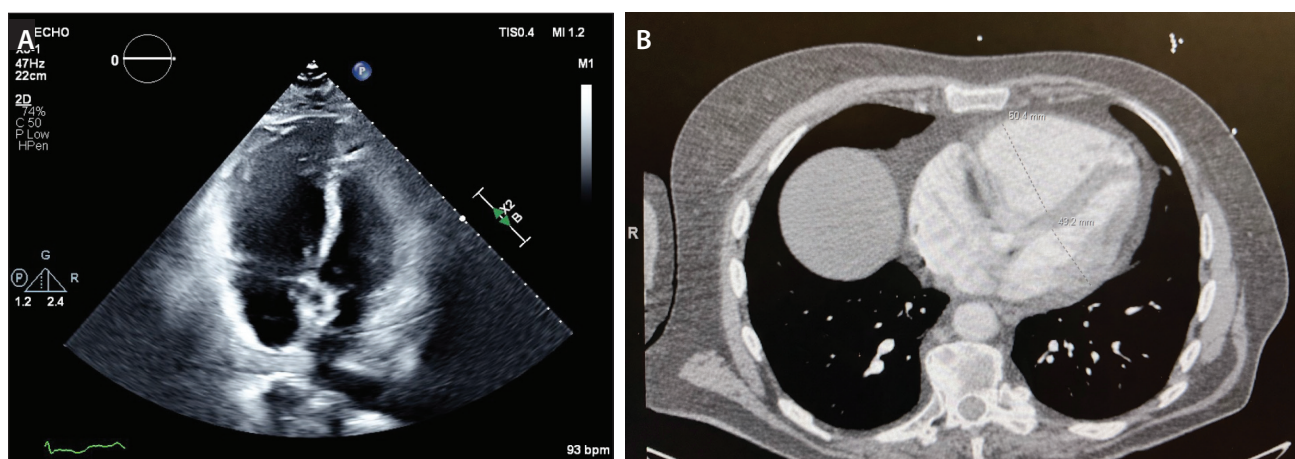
Echocardiogram (A) and CT image (B) showing RV dilation with an RV/LV ratio of 1.4.
